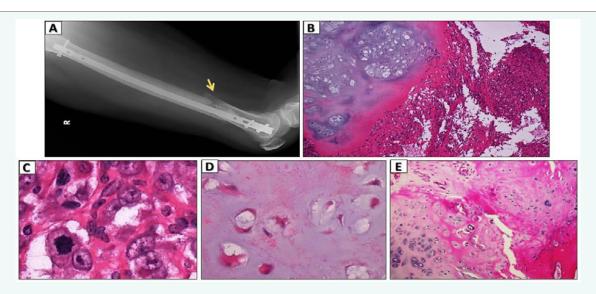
X-ray of the pathological fracture and pathological examination of the tumor
